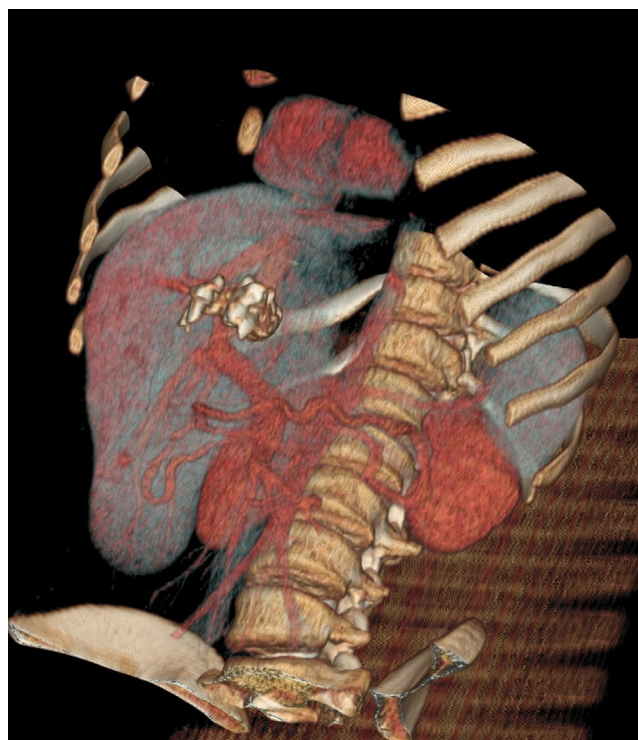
The teeth within the mass at CT exam – VR reconstruction.
